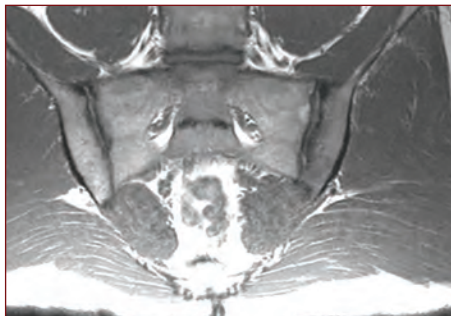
The T1W-SE sequence of the first MRI scan shows some irregularity of the left iliac cortex but without definite structural change.
